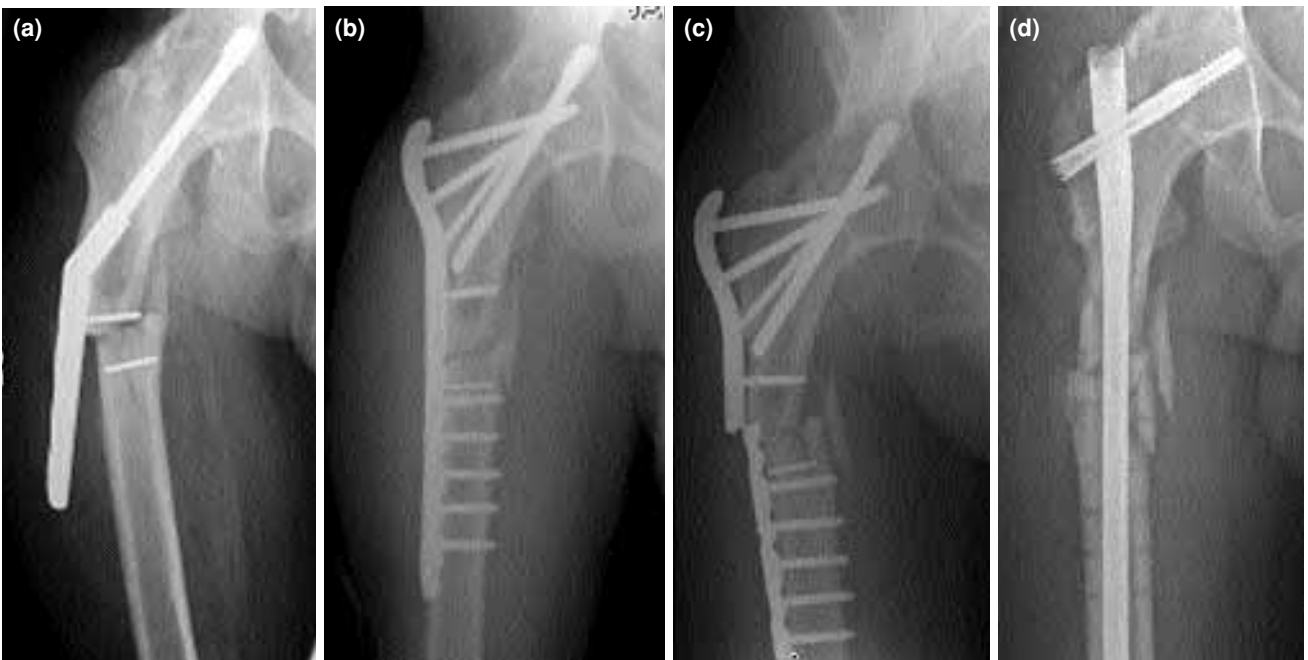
(a) Subtrochanteric femur fracture below the hip arthrodesis in case 3. (b) Radiograph after open reduction and internal fixation with a proximal femoral locking plate. (c) Radiograph showing failure of the hardware two weeks after the initial operation. (d) Radiograph after revision surgery, with all the previous implants removed, and a cephalo-medullary nail placed.
